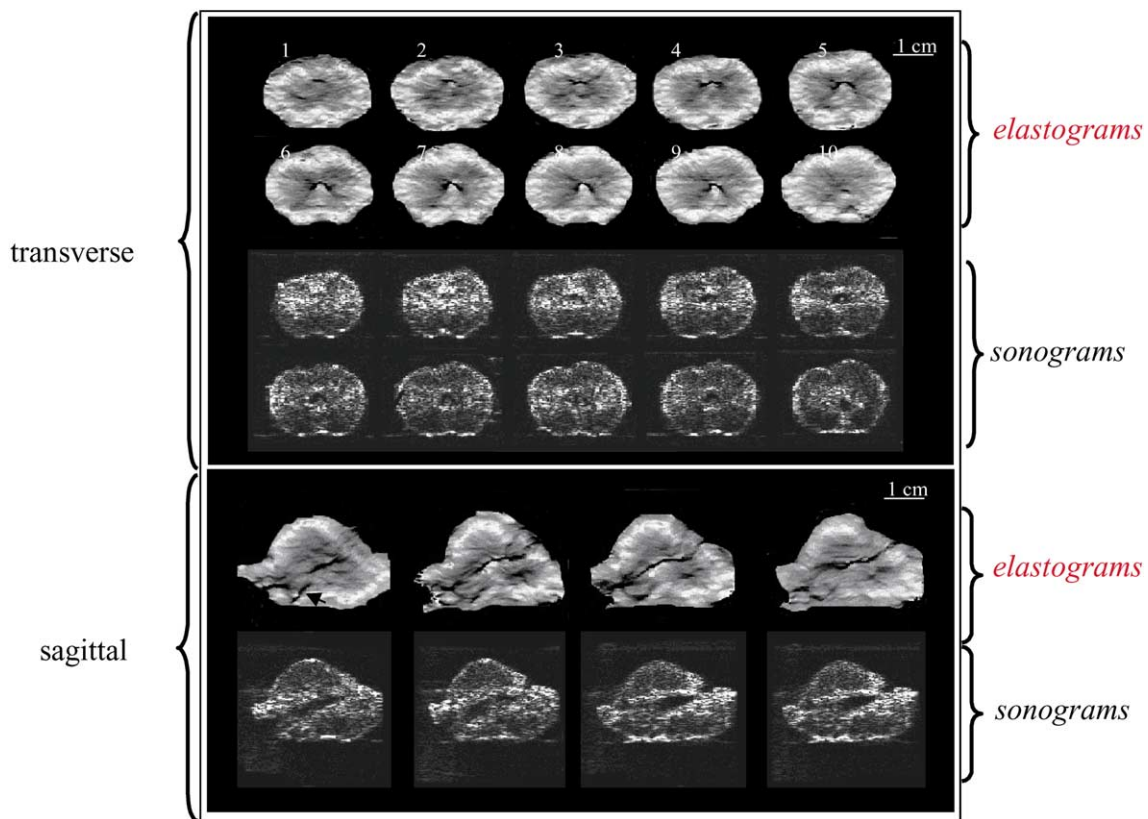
Matching elastograms and sonograms obtained from 1 mm equally spaced parallel transverse and sagittal cross-sections of a typical canine prostate at 5 MHz. The prostate size is approximately $3 \times 3 \times 3 \text{ cm}^3$. The elastograms are displayed using a reversed gray-scale map where white means stiff and black means soft [49]. Note the clear depiction of the urethra, consistently stiffer outer gland and softer inner gland, the soft acini and the stiff verumontanum in the corresponding elastograms.
